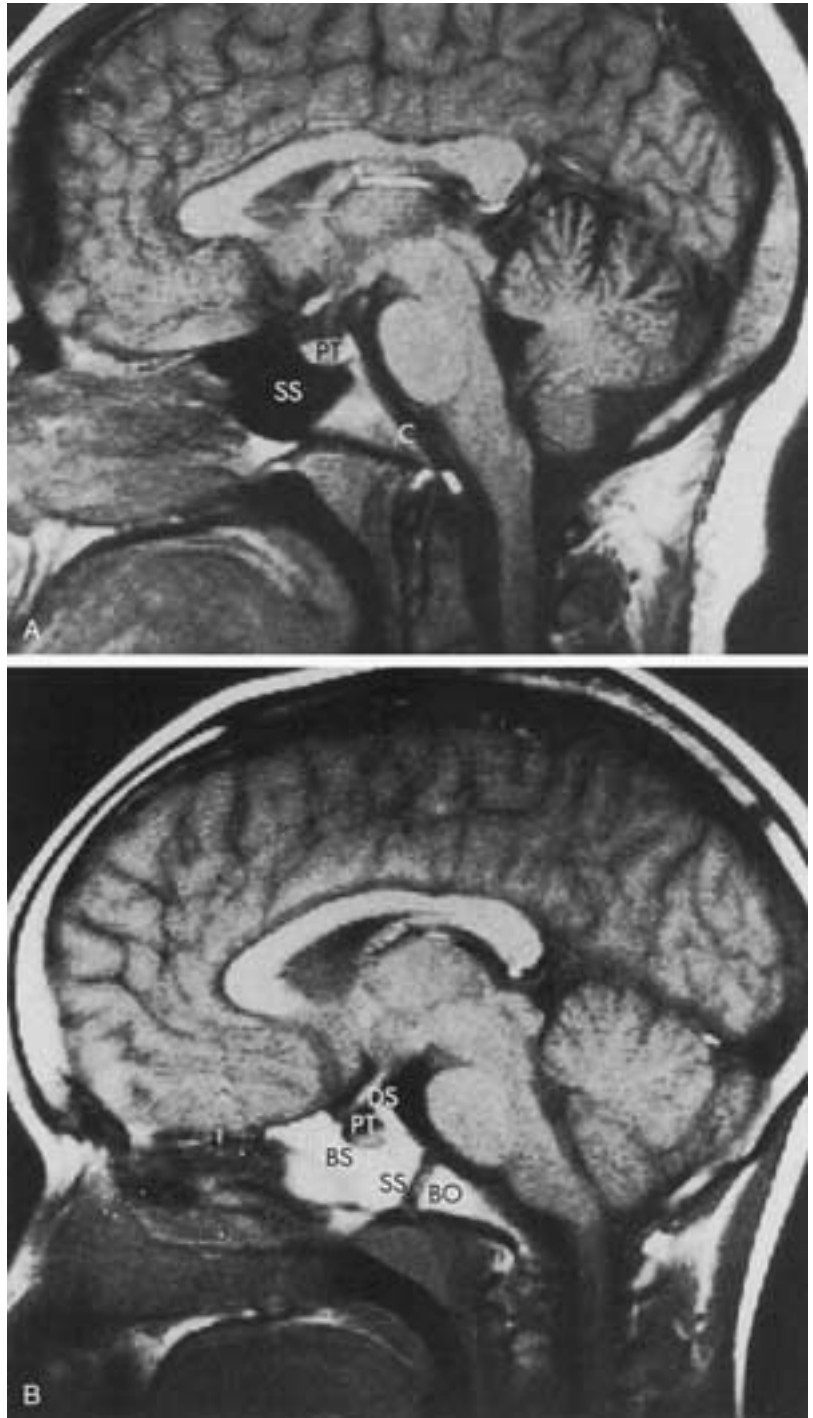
A, Midline sagittal T1-weighted MR image of the skull base in an adult. *PT*, Pituitary within the sella turcica; *SS*, sphenoid sinus; *C*, clivus. B, Midline sagittal T1-weighted MR image of the skull base in a child. *DS*, Dorsum sellae; *PT*, pituitary within the sella turcica; *BS*, basisphenoid; *SS*, sphenococcipital synchondrosis; *BO*, basiocciput.
